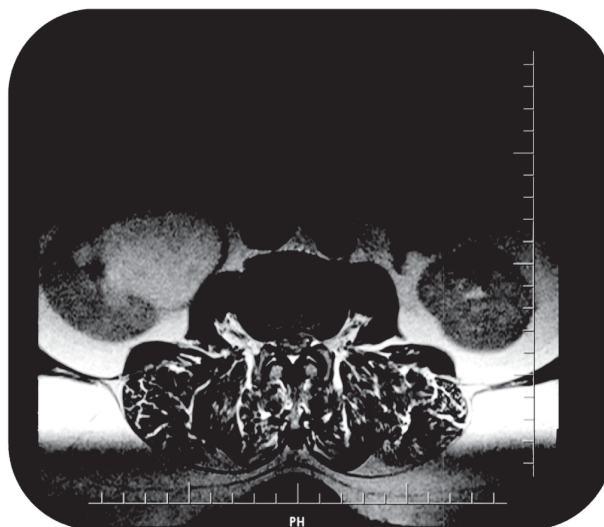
Lumbar spine MRI showing dilated right renal pelvis , which was confirmed to be due to PUJ obstruction by an IVU.
